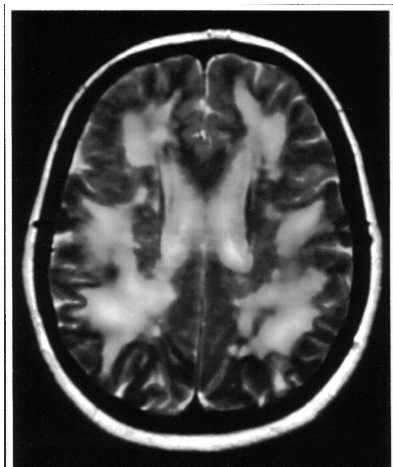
MRI of one of our patients with gluten sensitivity, episodic migraine-like headaches and white matter abnormalities.¹⁷ The patient remains asymptomatic 5 years after the diagnosis of gluten sensitivity and the introduction of gluten free diet. The clinical and radiological characteristics distinguish this entity from MS. The response to diet, lack of family history and absence of progression exclude CADASIL as an alternative diagnosis.
